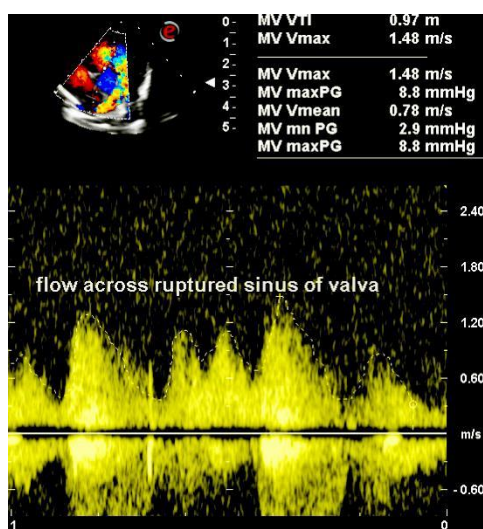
Continuous wave doppler imaging of flow across ruptured sinus of valsalva. Peak/mean gradient across rupture sinus of valsalva was 8.8/2.9 mmHg.
